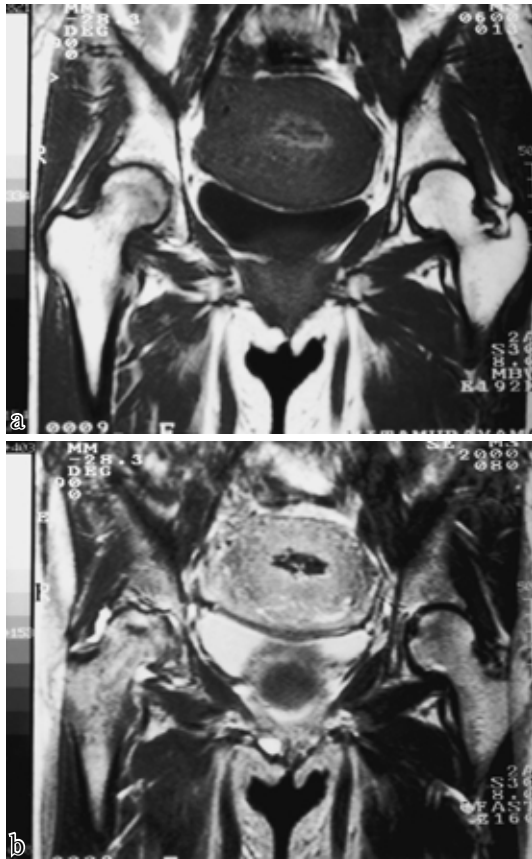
MRI findings in case 1 (9 weeks after onset)
